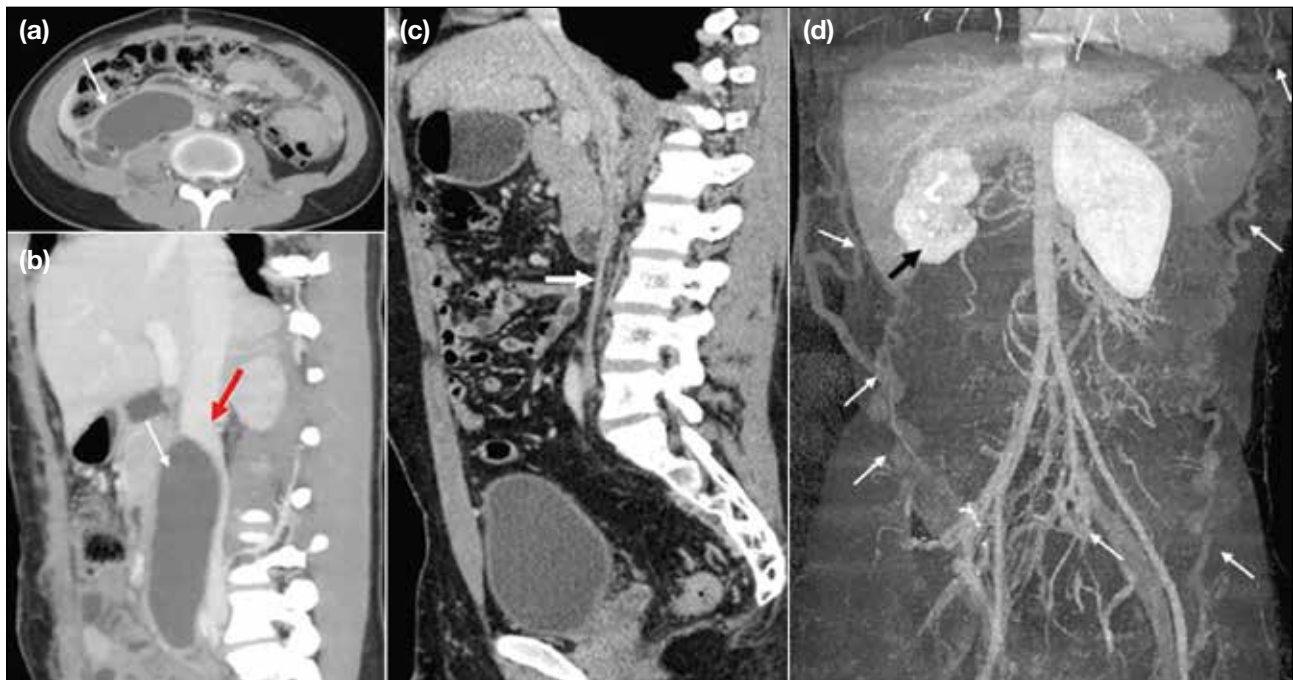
Immediate postsurgical complications on day 8 after para-aortic nodal dissection. (a) Axial and (b) sagittal contrast-enhanced computed tomography (CECT) images of the abdomen show a large hypodense collection (white arrows) causing extraluminal compression of the infrarenal inferior vena cava (IVC) [red arrow in (b)]. Delayed postsurgical complications in a case of carcinoma of the testis, status post-orchidectomy, and para-aortic lymphadenectomy demonstrate chronic IVC thrombosis with collateral formation. (c) Sagittal CECT image of the abdomen shows significant luminal narrowing of the IVC (white arrow). (d) Coronal maximum intensity projection image shows multiple dilated, tortuous collateral vessels in the pelvis and abdomen extending into the thoracic walls (white arrows), along with a contracted right kidney (black arrow).
